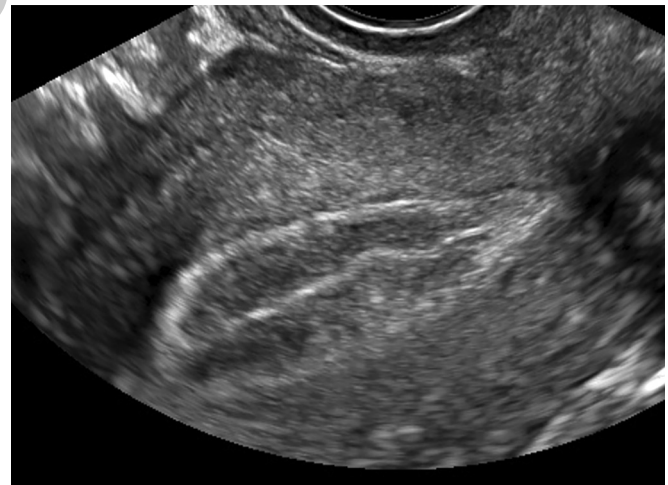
B-mode ultrasound image of grade-A endometrium.
